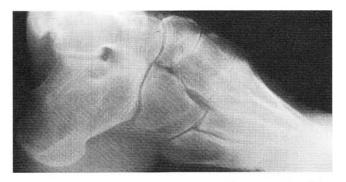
Lateral radiograph of severe neurologic cavus foot deformity, preoperative view.
